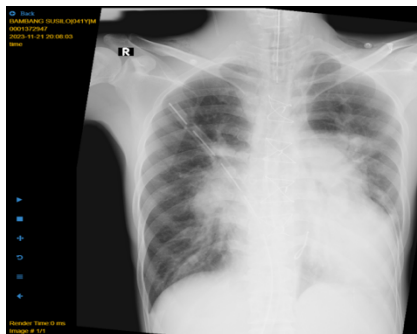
Chest X-ray, November 21, 2023
